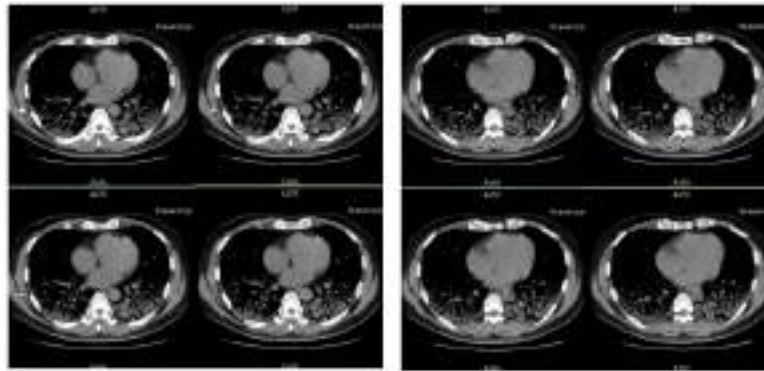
Chest CT Scan, 10 March 2020 (Illness Day 7, Hospital Day 1).
